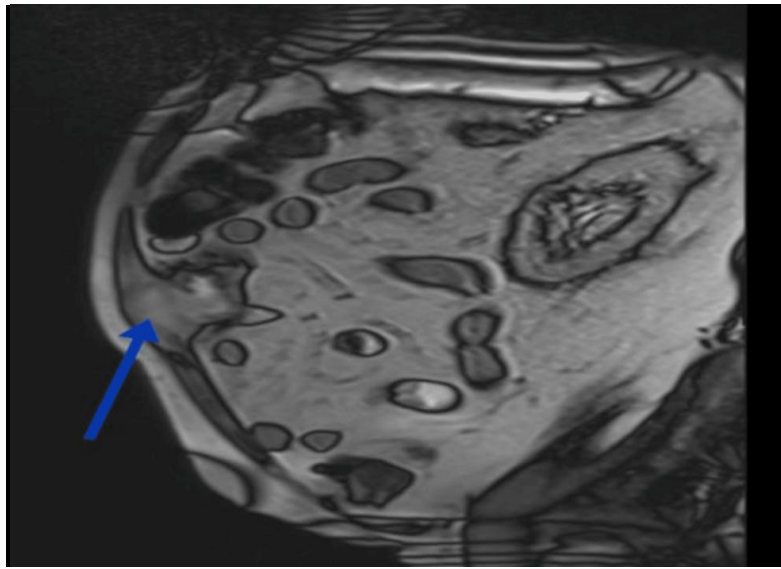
Sagittal view of MRI abdomen with blue arrow pointing at the lesion
